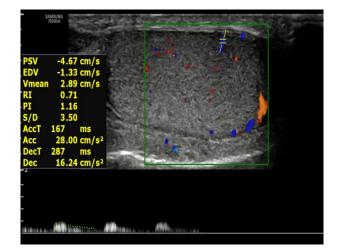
Trans-scrotal sonographic evaluation showing spectral doppler assessment of testicular parenchyma vessel.
